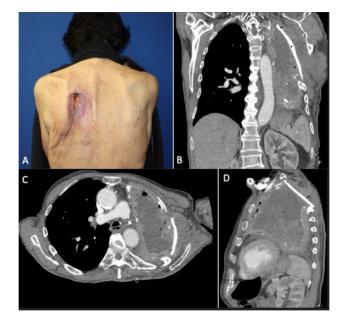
(A) Pre-operative left posterior thorax wound; (B-D) Coronal, axial, and sagittal sections of pre-operative CT chest demonstrating intra-thoracic defect.
